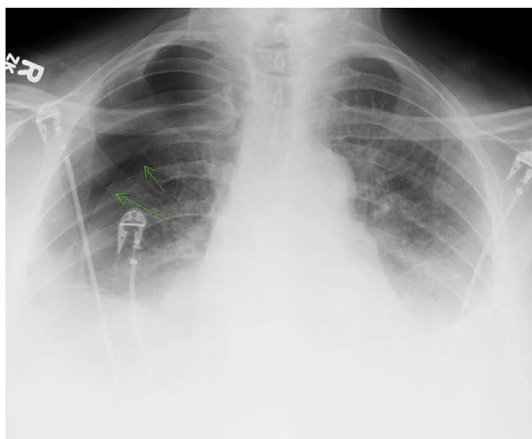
AP Chest X-ray of the patient on admission, remarkable for images suggesting bilateral pleural effusions and right sided pneumothorax (marked by arrows).
